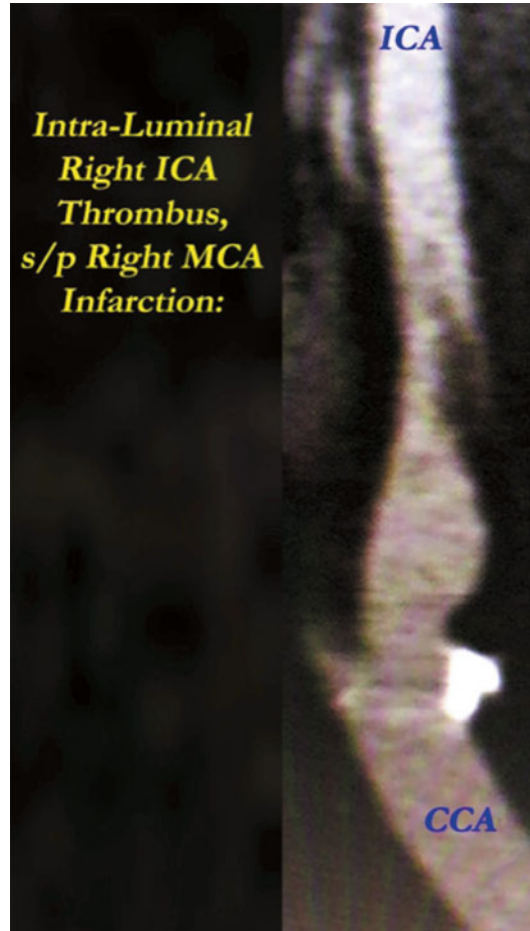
Intraluminal thrombus within right ICA seen on CT angio after right MCA infarction; this thrombus spontaneously resolved and disappeared over 2 weeks without further complication
